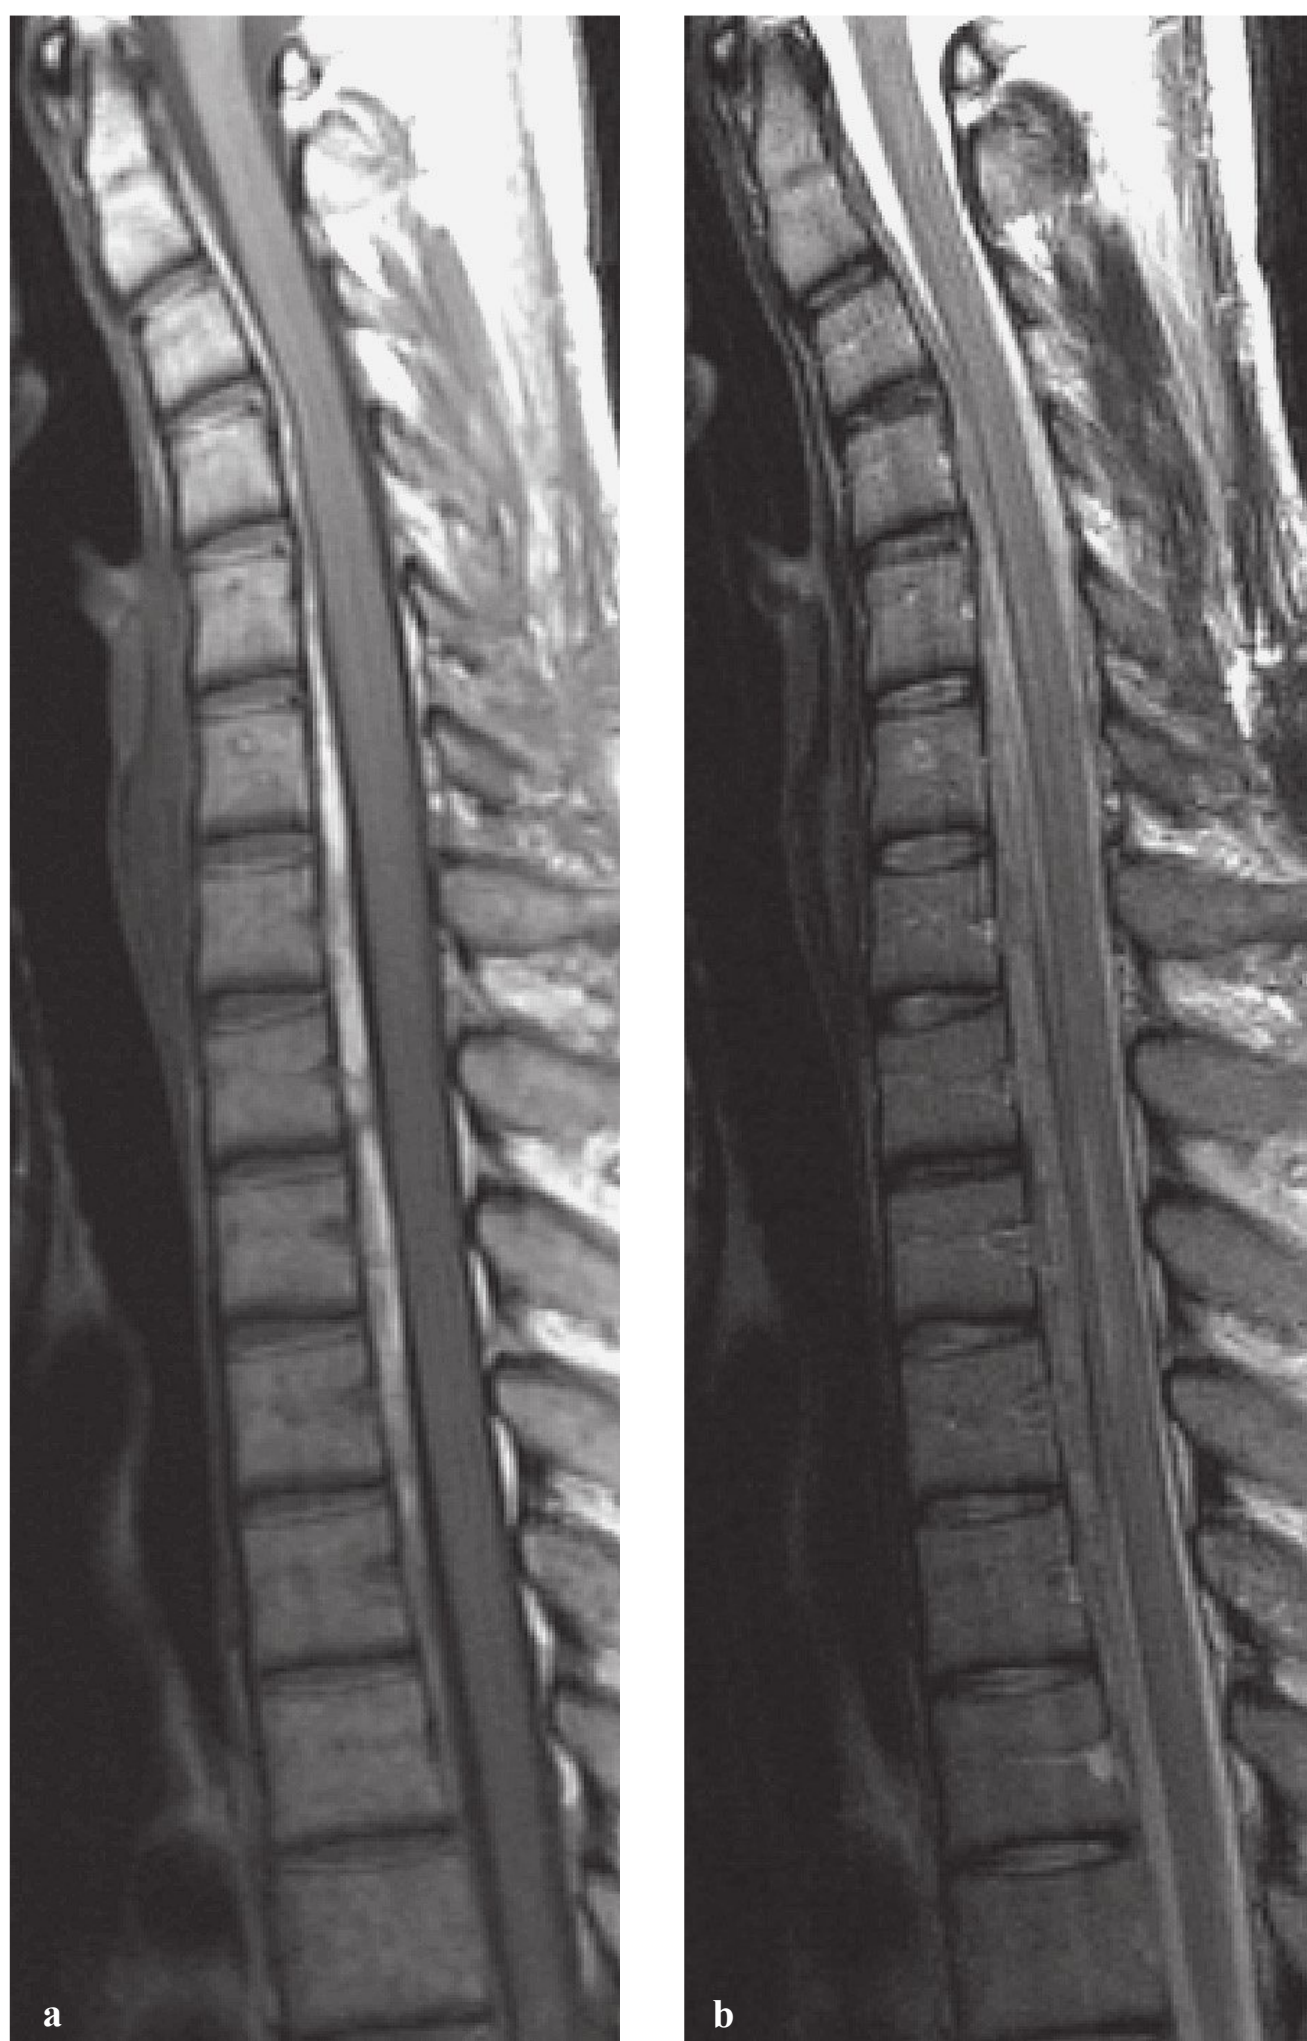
(a,b) T1-weighted magnetic resonance imaging demonstrating increased signal intensity suggestive of hemorrhage. (Reproduced from Uhlenbrock D. MR Imaging of the Spine and Spinal Cord. Stuttgart, Germany: Georg Thieme Verlag; 2004: Fig. 8.2a,b, with permission.)
